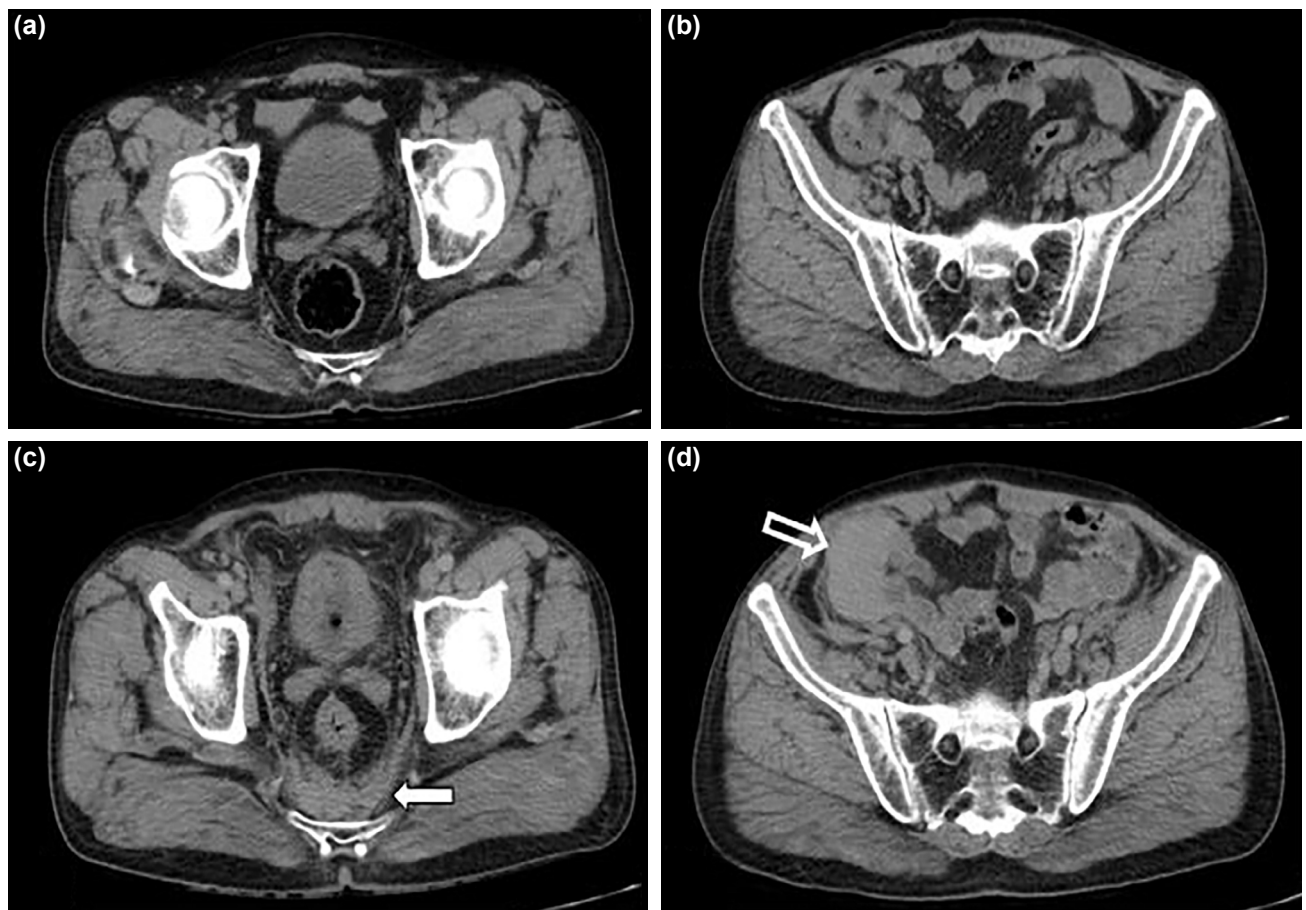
Presacral hemorrhage and intra-abdominal hematoma. (a, b). Normal appearance on the initial unenhanced abdominal computed tomography (CT). (c) and (d). On the 3rd day, contrast-enhanced abdominal CT revealed presacral hemorrhage (arrow) and a free fluid (hollow arrow) that may be compatible with intraabdominal high-density hematoma.
